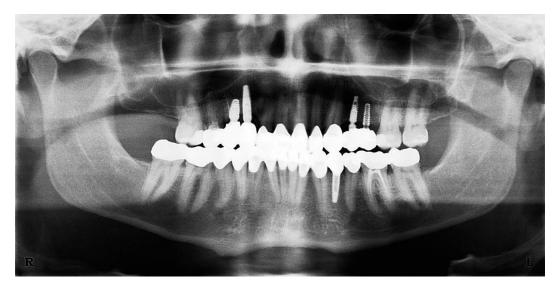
Two-year panoramic radiograph
